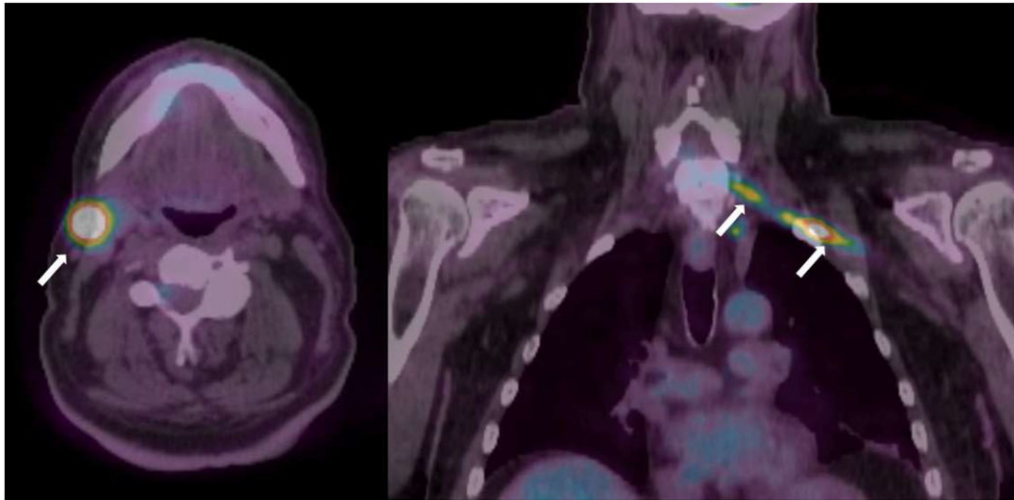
Fusion PET/CT scan of whole body. There was increased ¹⁸F-FDG uptake in right cervical lymph node (2.2 cm) and extensive FDG uptake along the C7–T1 nerve roots extending into the left brachial plexus.
